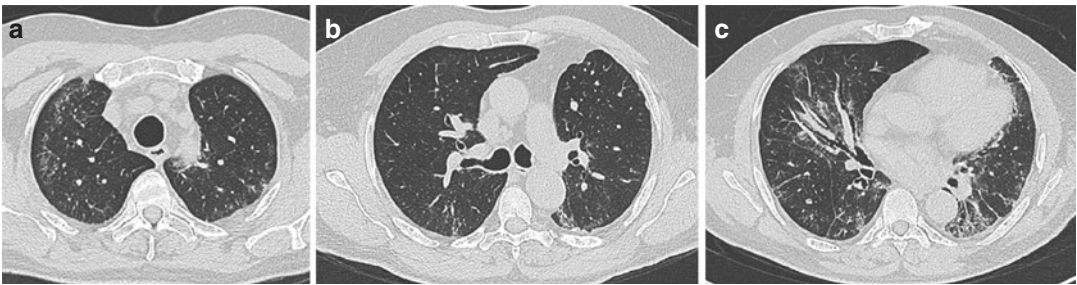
(a–c) Sample cuts from a high-resolution chest CT scan of a myositis ILD patient with biopsy-proven UIP showing a peripheral distribution and reticulations but also notable for significant ground glass opacities. (a) upper lung, (b) mid lung, (c) lower lung
